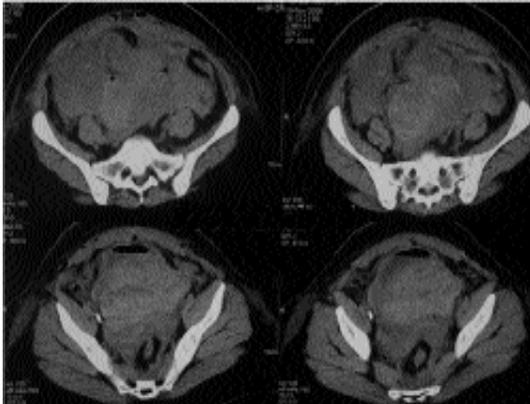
Noncontrast-CT revealed intraabdominal and pelvic hemorrhages
